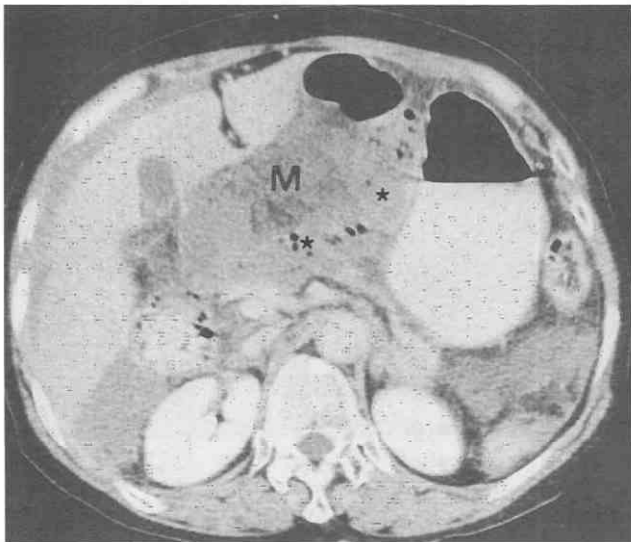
Internal (lesser sac) hernia with strangulated small-bowel obstruction. The dilated small-bowel loops (*asterisks*), herniated in the lesser sac, are poorly enhanced because of intestinal strangulation. Diffuse regional mesenteric haziness (M) is also present. (From Ha HK, Kim HS, Lee MS, et al: Differentiation of simple and strangulated small bowel obstructions: Usefulness of known CT criteria. *Radiology* 204:507-512, 1997.)
